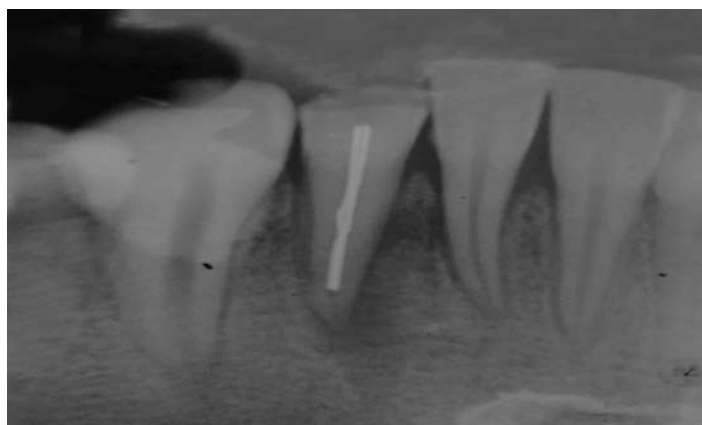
Diagnostic radiograph
